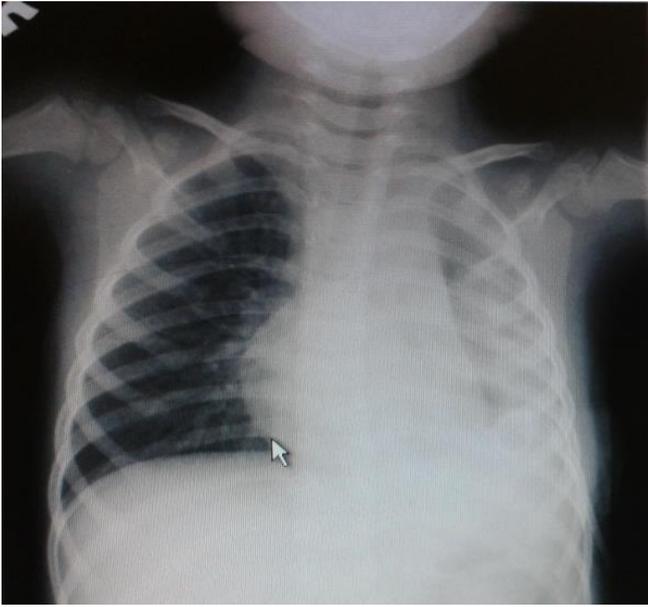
Chest x-ray on day 10 of treatment
